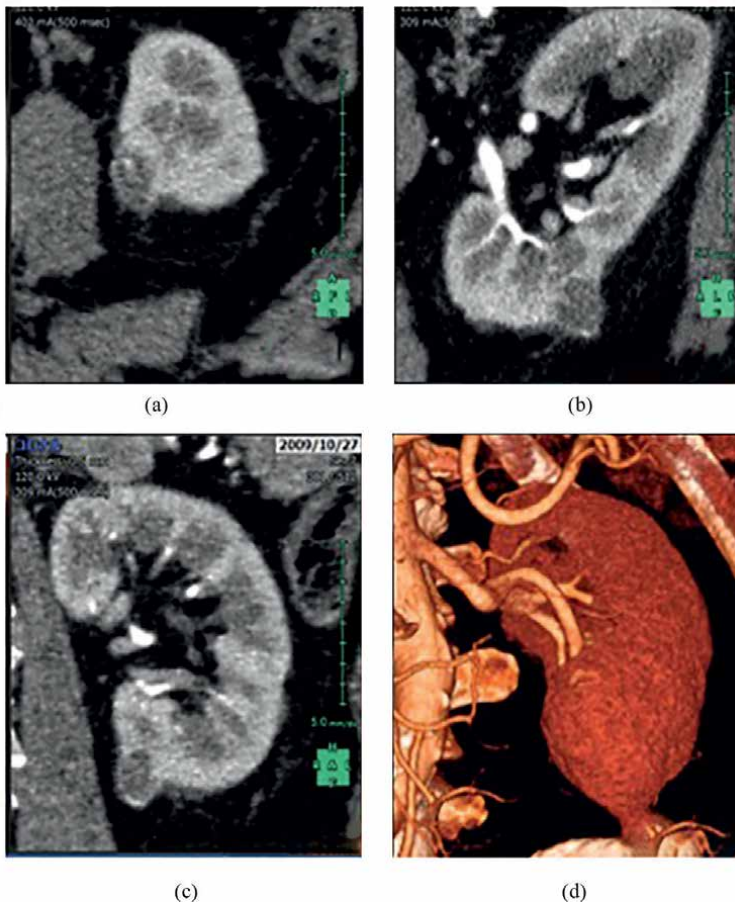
The comparison of two-dimensional (2D) images of CT with axial (a), coronal (b), and sagittal (c) images and 3D CT volume rendering image (d).
